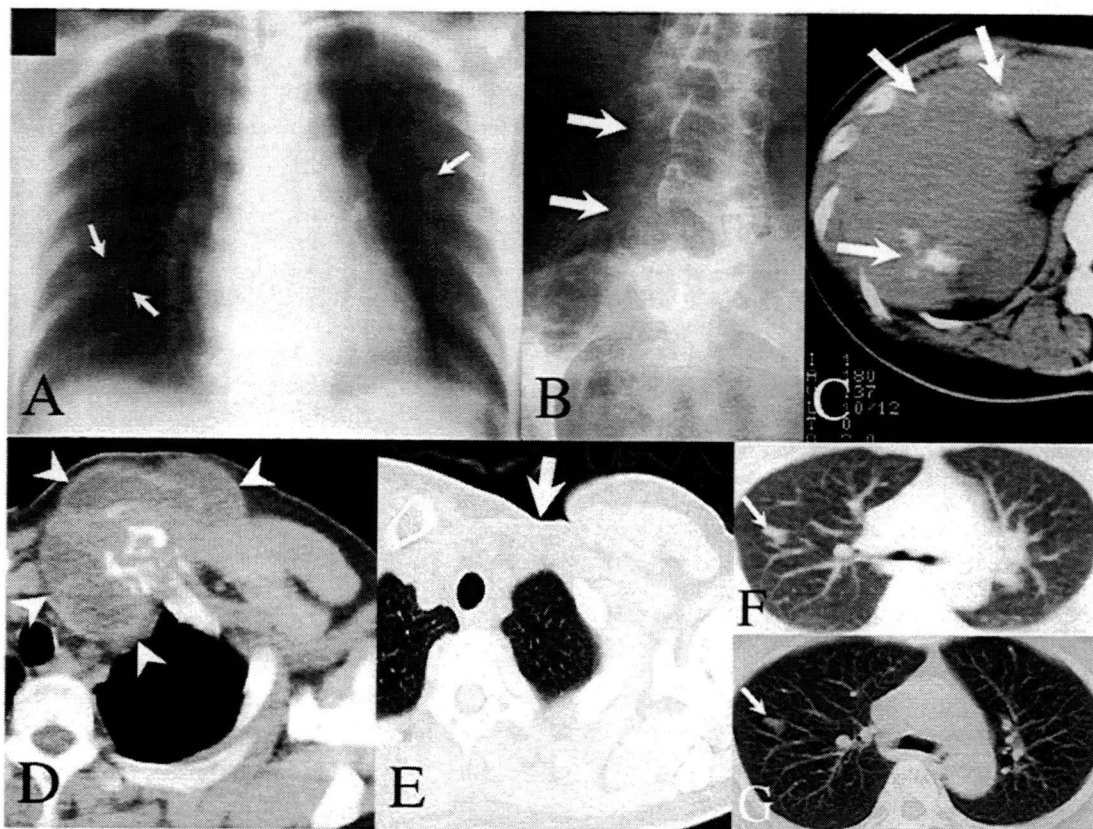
Imaging figures of case 1 (A to C) and case 2 (D to G). (A) Several nodular densities demonstrated by a chest X-ray tomogram (arrows). (B) Osteolytic destruction of the right lower lumbar vertebrae resulting from AE invasion of the pelvis (arrows), demonstrated by X ray 143 months after ABZ chemotherapy (September 2007). (C) Reduction in size of hepatic AE foci with calcification (arrows), demonstrated 130 months after ABZ chemotherapy (July 2000). (D) Chest CT scan demonstrating a mass with a heterogeneous density (arrowheads) at the left medial head of the clavicle. (E) CT scan image obtained 81 months after radical resection of the bone AE and ABZ chemotherapy (December 1999). A defect after complete removal of the lesion without relapse is demonstrated (arrow). (F) Chest CT scan image demonstrating multiple nodular densities of pulmonary AE (the arrow points to one of the lesions). (G) Chest CT scan image demonstrating multiple nodular densities with few changes 81 months after the time of diagnosis (December 1999) (the arrow points to one of the lesions).
